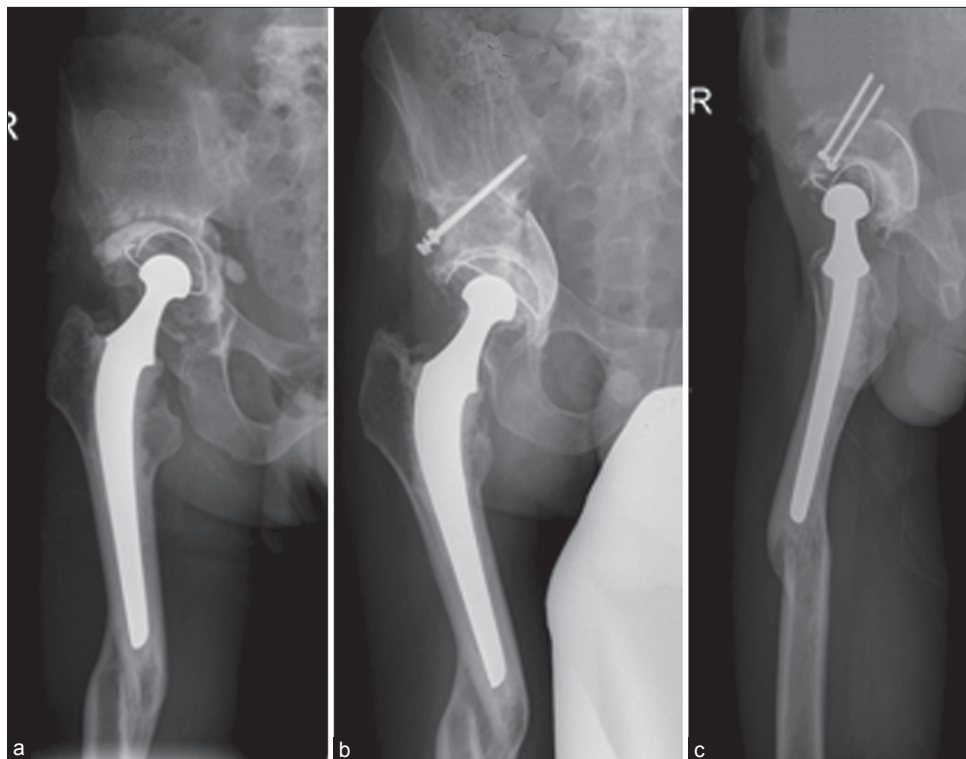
Preoperative X-ray (R) hip joint with thigh showing (a) aseptic loosening and Paprosky type 3a defect 6 years postoperative total hip replacement in a 37 year old male (b) 4 years followup (c) lateral view showing consolidation
